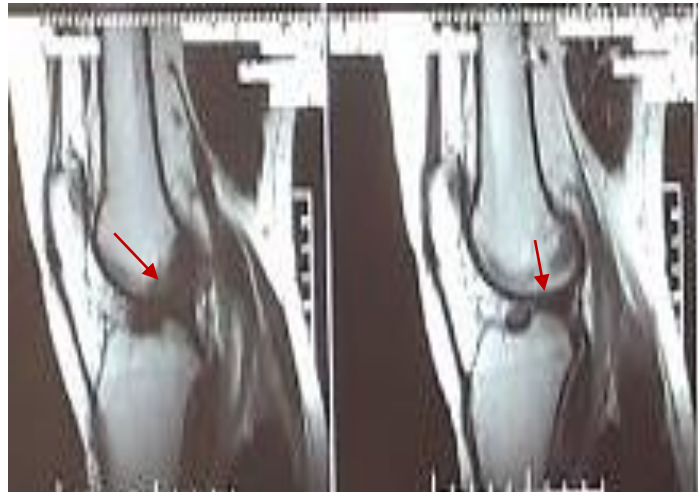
Image showing MRI finding of complete ACL tear (red arrow) which was confirmed on arthroscopy (black arrow)
